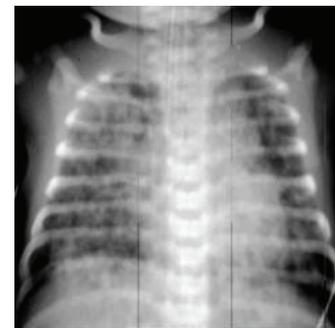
Chest X-ray showing fluffy shadows in lungs suggestive of meconium aspiration syndrome
